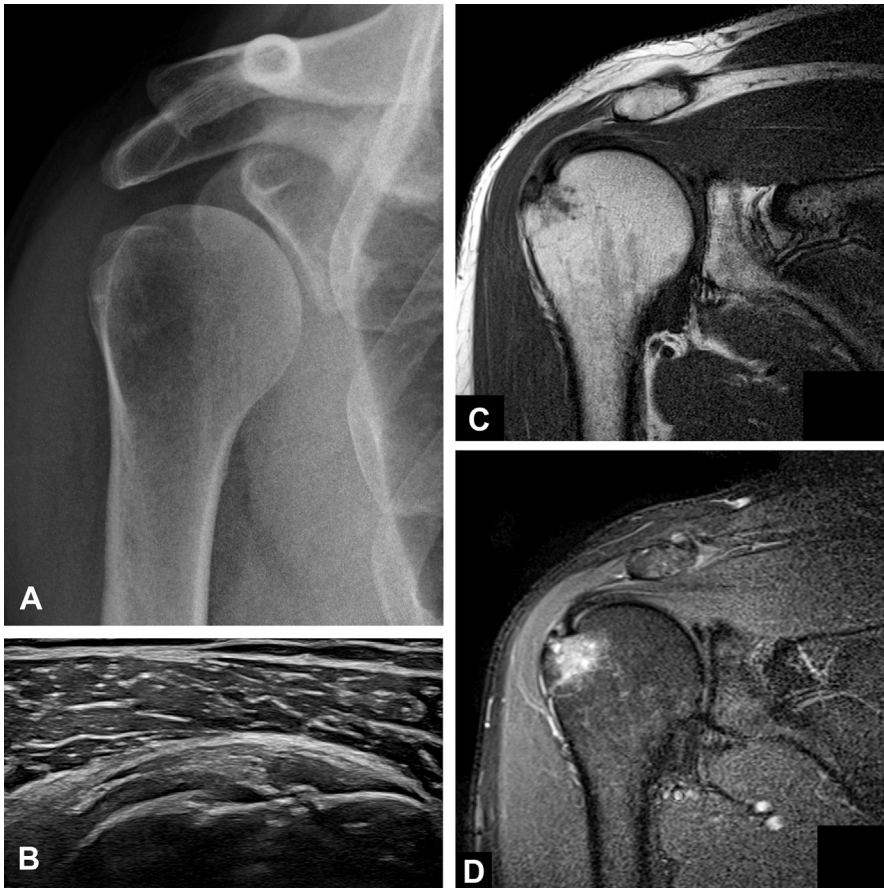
Unremarkable radiograph (A). Ultrasound (B) of the supraspinatus insertion shows multiple small calcifications and a cortical break with intraosseous extension of calcifications. No bursitis. Coronal T1TSE (C) and T2fat-sat MR images (D) show SSP enthesitis and several subchondral cysts and extensive bone marrow edema at the footprint.
